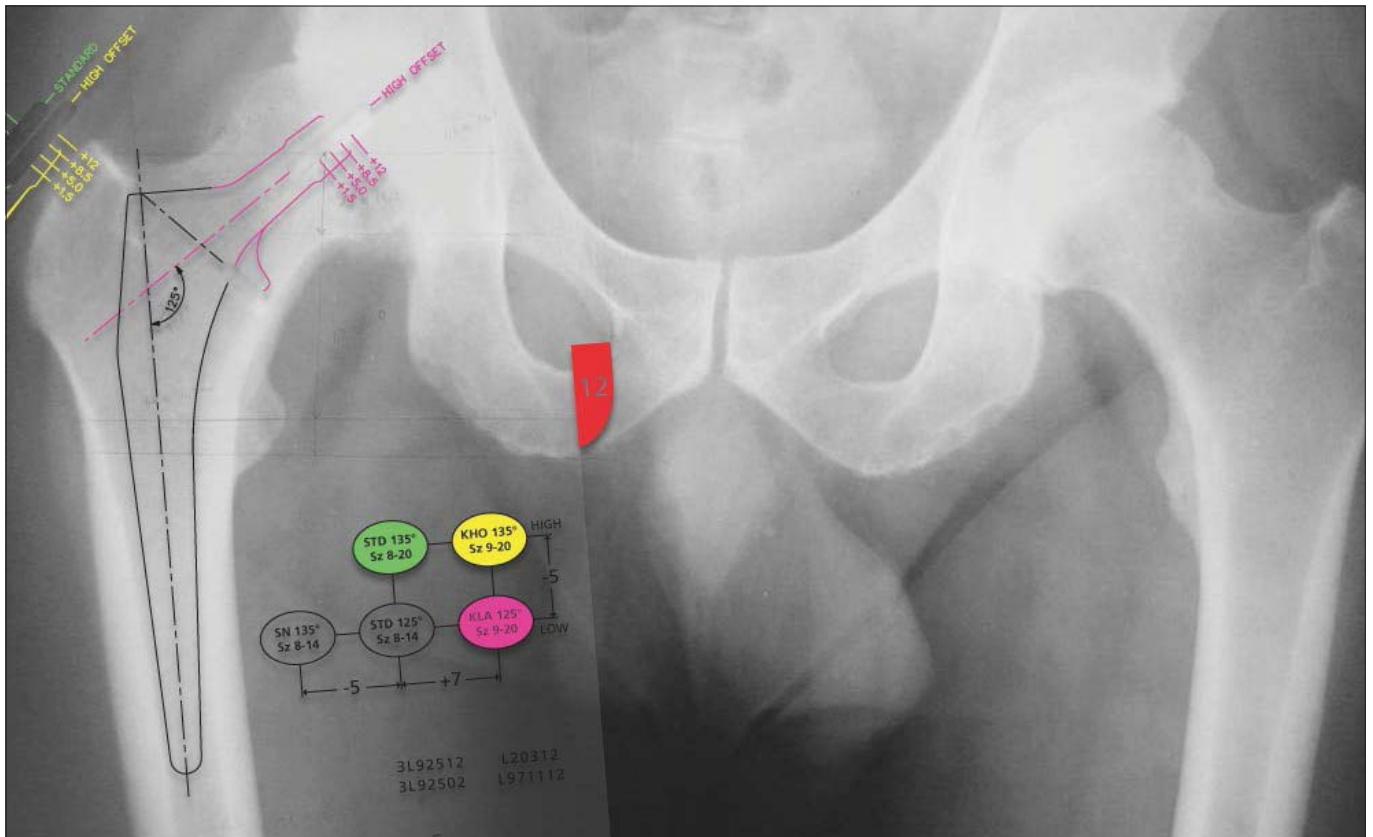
Pelvis X-ray for templating.
